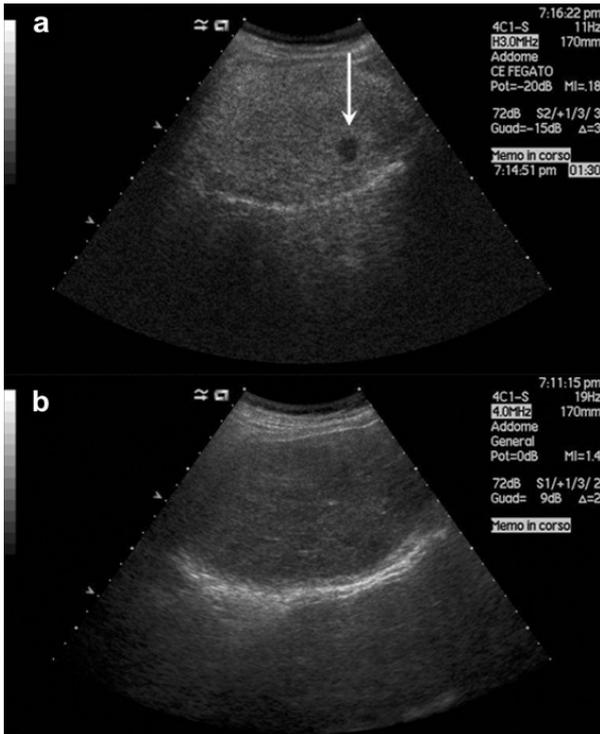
Liver metastasis. a. CEUS: a small focal hypoechoic focal lesion of liver dome (arrow) is well-detectable during the sinusoidal contrast-enhanced phase. b. US: the lesion was not detected during conventional ultrasound scans of the liver.
